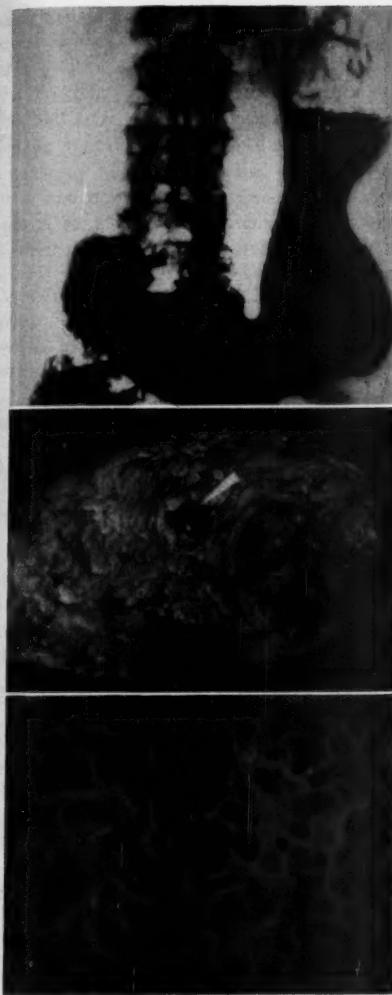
(Top). X-ray revealed a tumor of the fundus of the stomach thought to be malignant.
